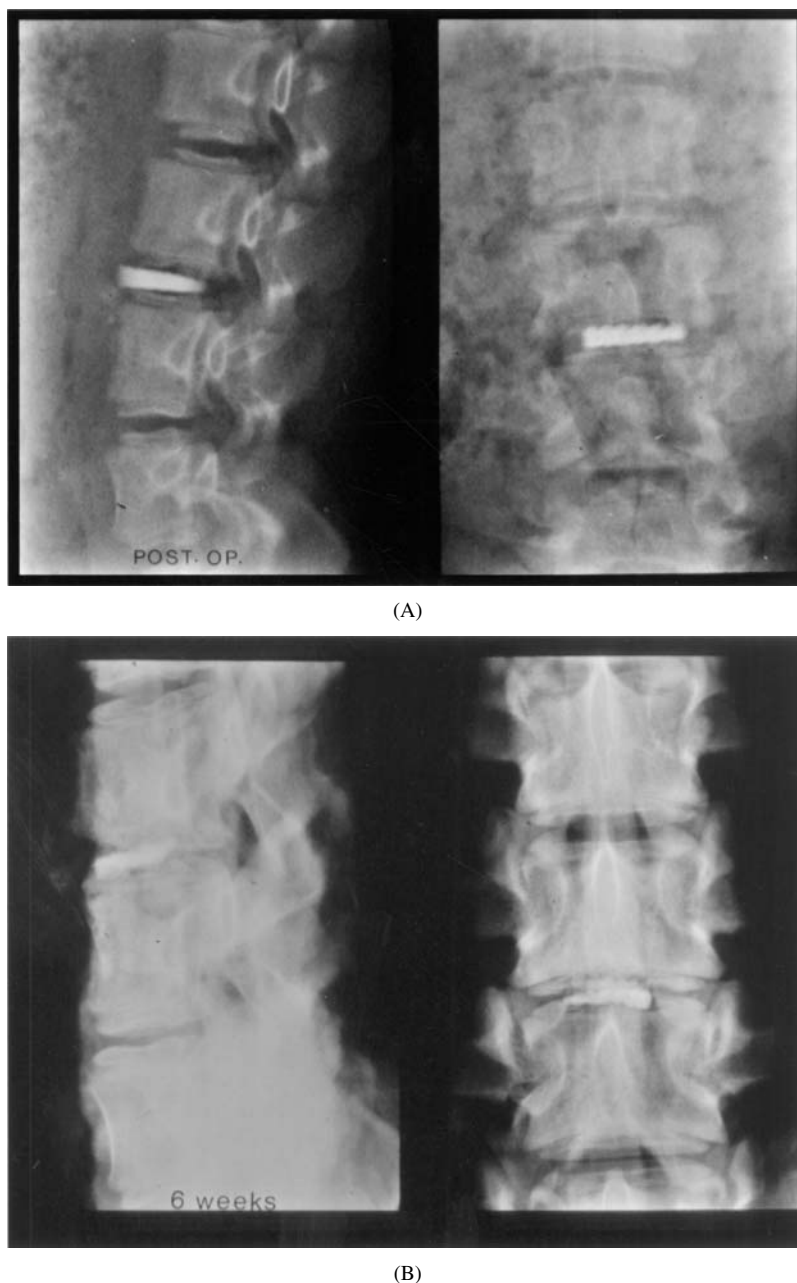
(A) Postoperative radiograph of lumbar spine. HA implant is placed in the emptied disc space between the lumbar bodies of L 4 and L 5. (B) radiograph after 6-week follow-up. HA implant has not been fragmented.
